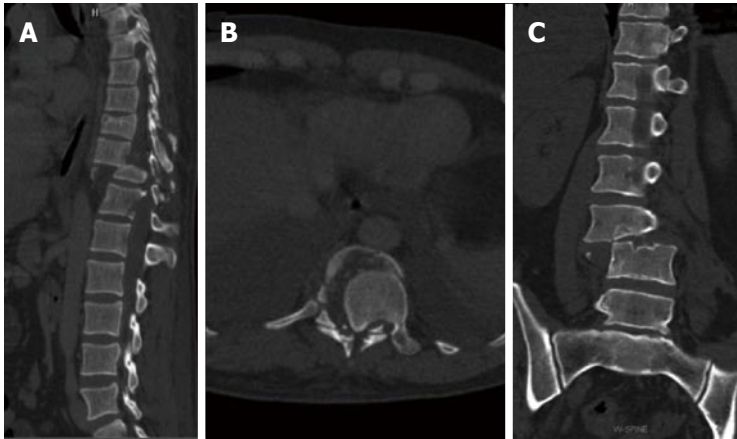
Type C3 rotational injury. Sagittal CT image (A), axial computed tomography (CT) image (B) and Coronal CT image (C) show shear slice fracture [C3.1 in (A) and (B)] and shear oblique fracture [C3.2 in (C)].
